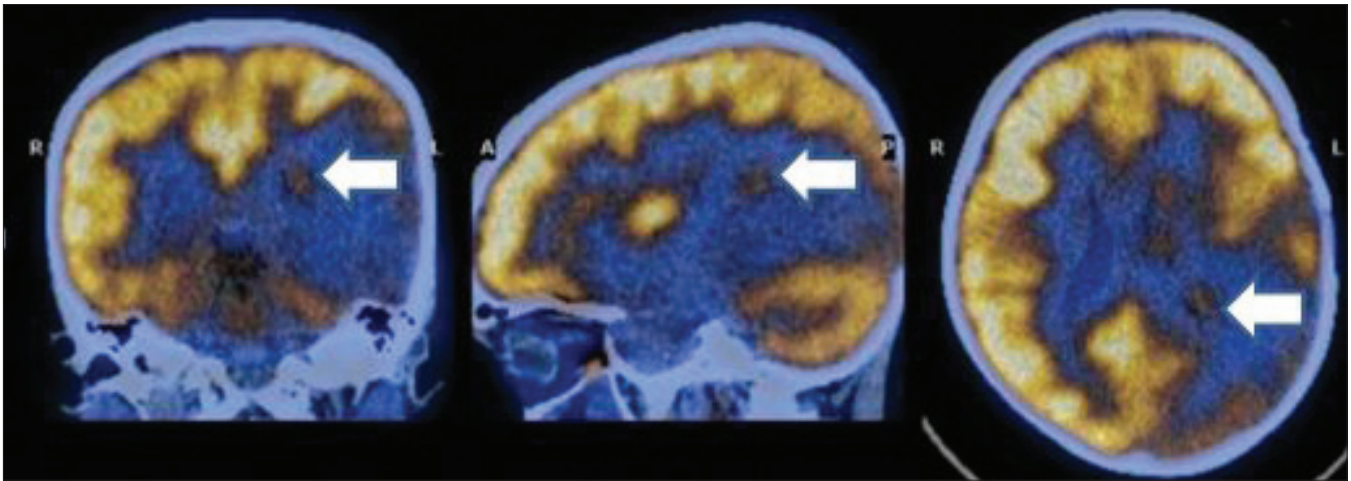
Coronal, Saggital and Transaxial fused F-18 FDG PET/CT images
